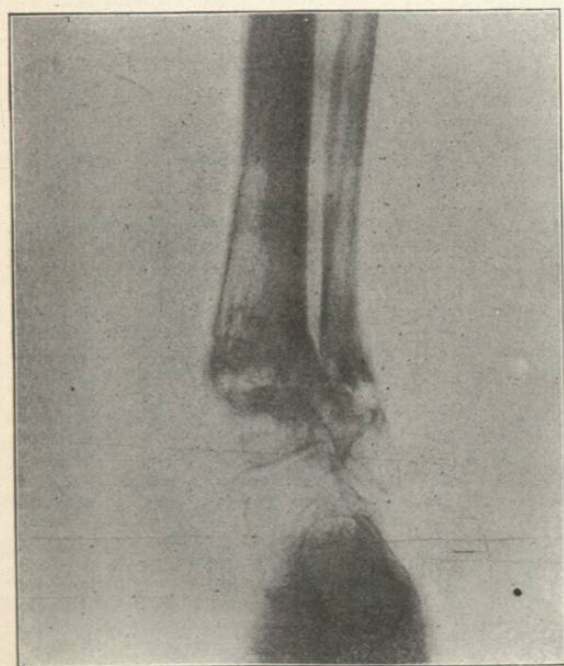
Radiograph, showing track of bullet through lower ends of tibia and fibula. Wound was caused by a Mauser bullet February 24, 1901, at a distance of 100 yards. The fracture extended down into the ankle joint. Remote effects: osteomyelitis of fibula; partial ankylosis of ankle; unable to bear any weight on foot. Radiograph taken nine months after injury.
